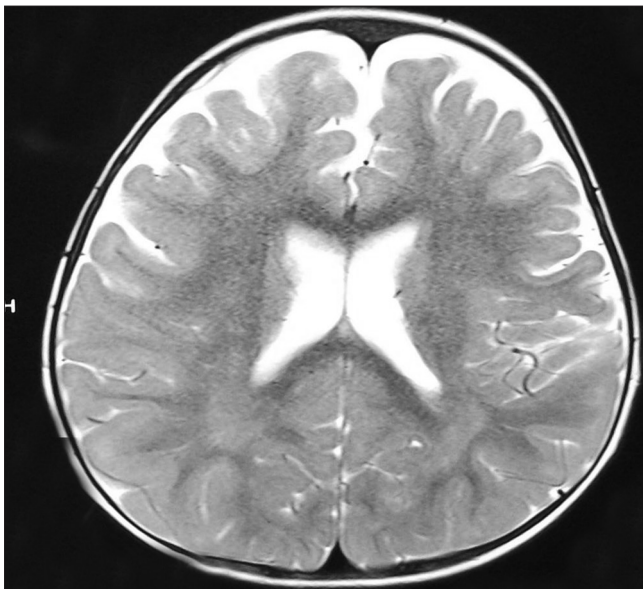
T2-weighted magnetic resonance imaging (MRI) showing signal changes in bilateral peritrigonal regions
